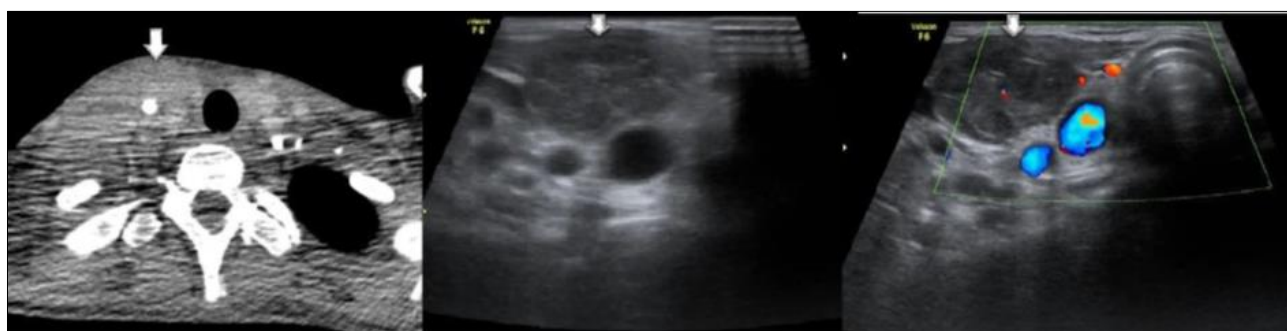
Axial CT scan with soft tissue window settings and cervical ultrasound with and without color Doppler
